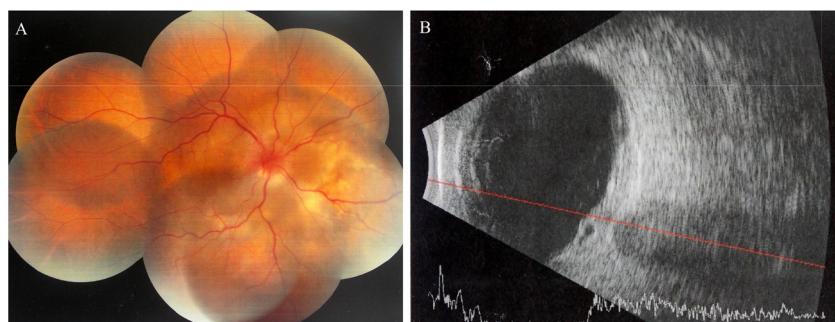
Fundoscopy evaluation of the right eye showing cream colored lesions involving nasal, superior and temporal periphery. (A) Ultrasound image with choroidal tumor with irregular borders (B).
